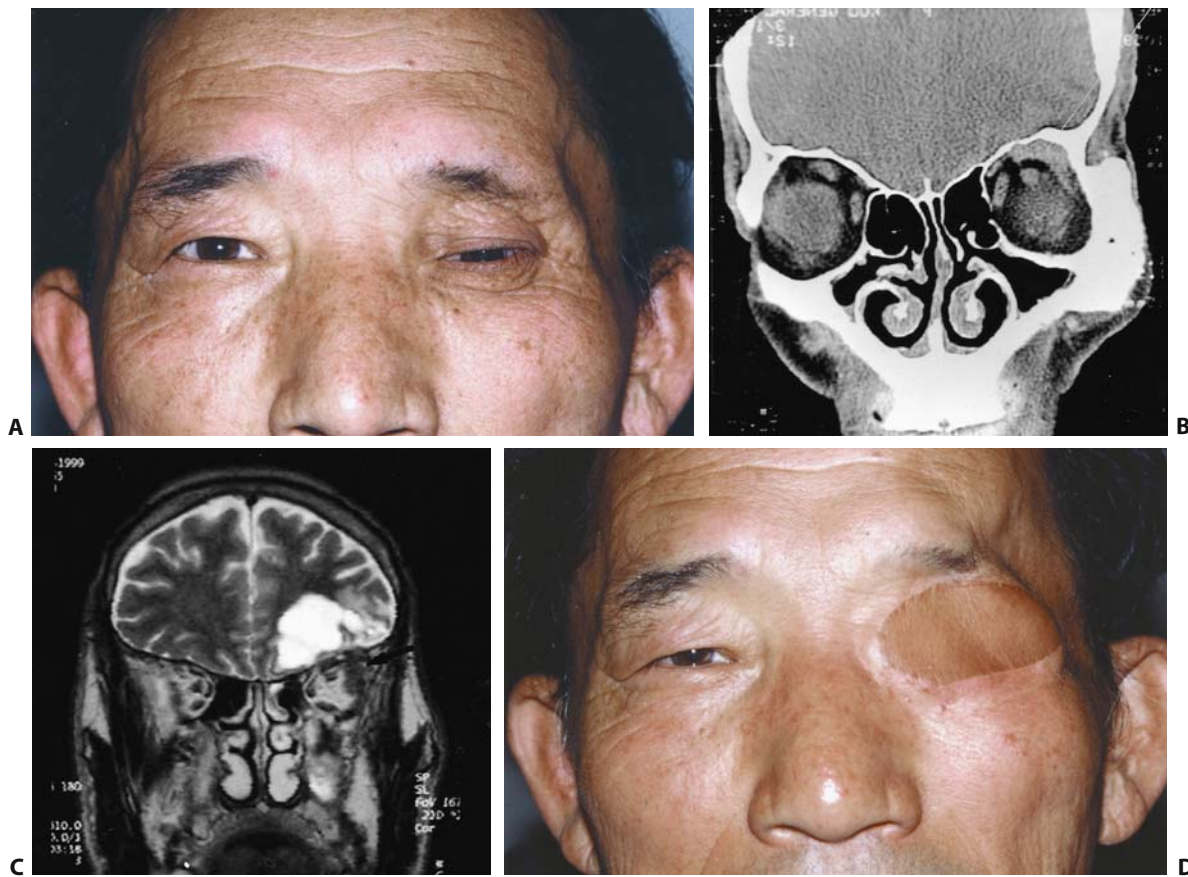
Adenoid cystic carcinoma. (A) A 57-year-old man had undergone tumor removal by lateral orbitotomy 12 years earlier for adenoid cystic carcinoma of the left lacrimal gland. There were perineural and adjacent bony invasion at that time. He received radiation therapy right after the operation. Upon developing motor aphasia, he visited our clinic. There is 2 mm of proptosis in his left eye. The left upper eyelid is ptotic and hard mass is palpable in the upper lid. The upward movement of the eye is restricted. (B) Coronal CT scan of the orbit shows tubular mass in superolateral portion of the left orbit with excavation of adjacent bone. (C)
